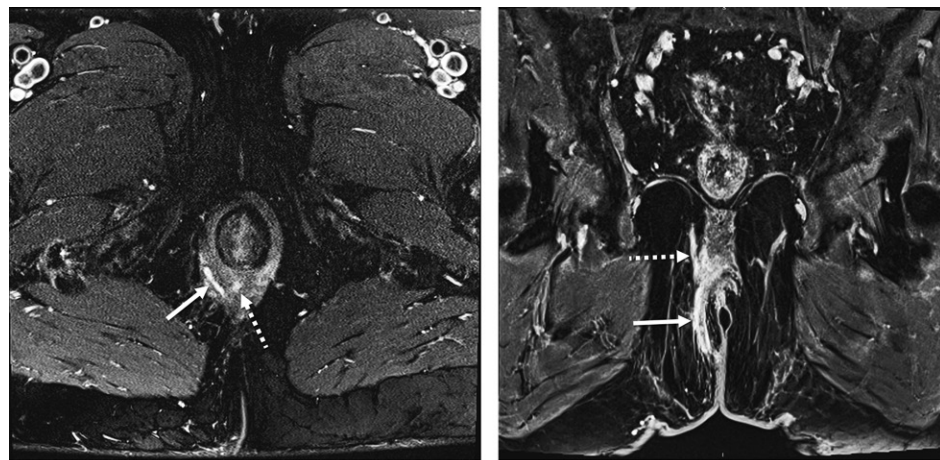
Perianal Crohn disease. (a) Axial T2-weighted fat-suppressed MR image shows a transphincteric perianal fistula, which arises from the posterior midline (6-o'clock position) (dashed arrow) and crosses the external sphincter on the right (solid arrow). (b) Coronal contrast-enhanced fat-suppressed T1-weighted MR image shows inferior extension of the fistula into the inferomedial gluteal fold (solid arrow) and superior extension into the ischioanal fossa (dashed arrow).
